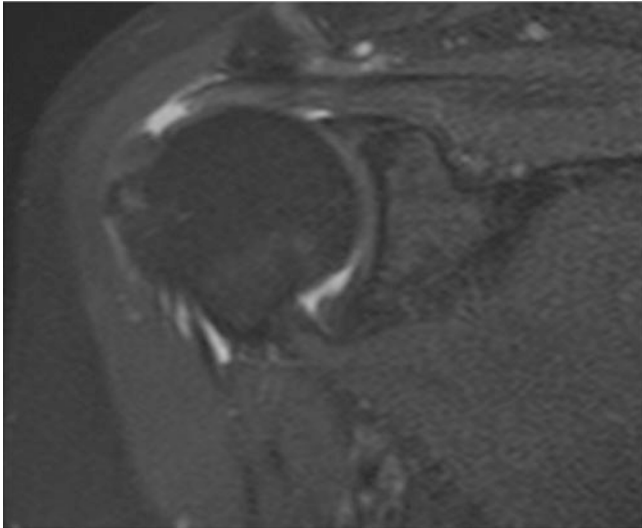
MRI image in coronal STIR showing a partial lesion of the supraspinatus tendon on the bursal side
